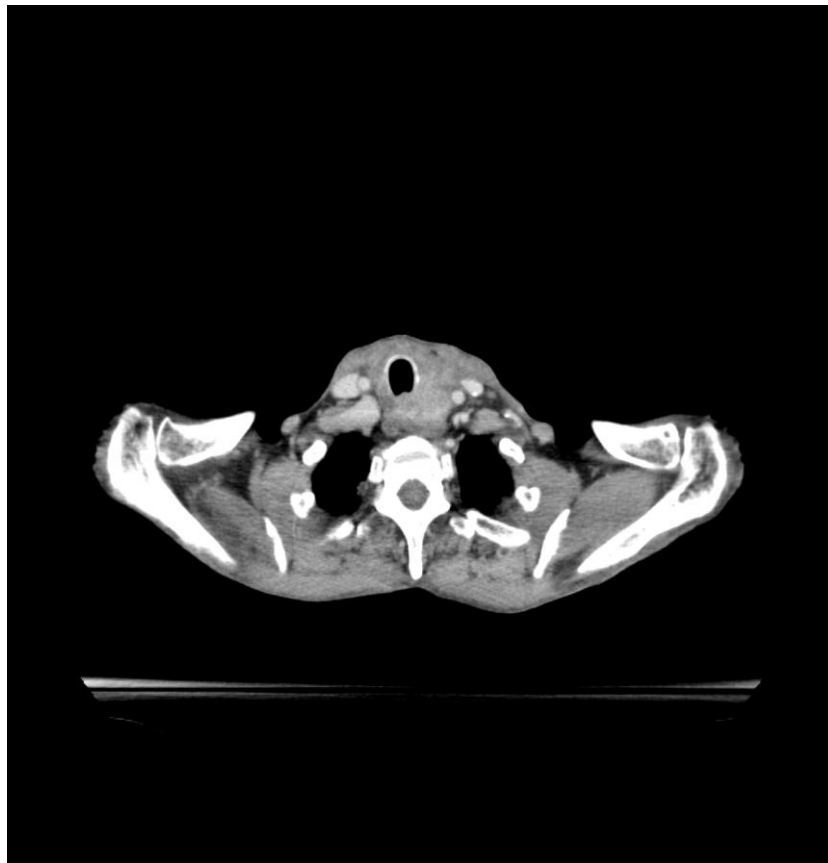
Preoperative CT: lesion in the left lobe of the thyroid gland.
